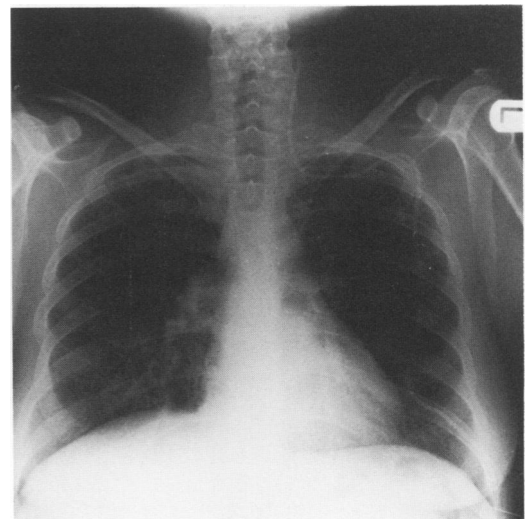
Chest radiograph from case no. 1 after migration into jugular vein.
